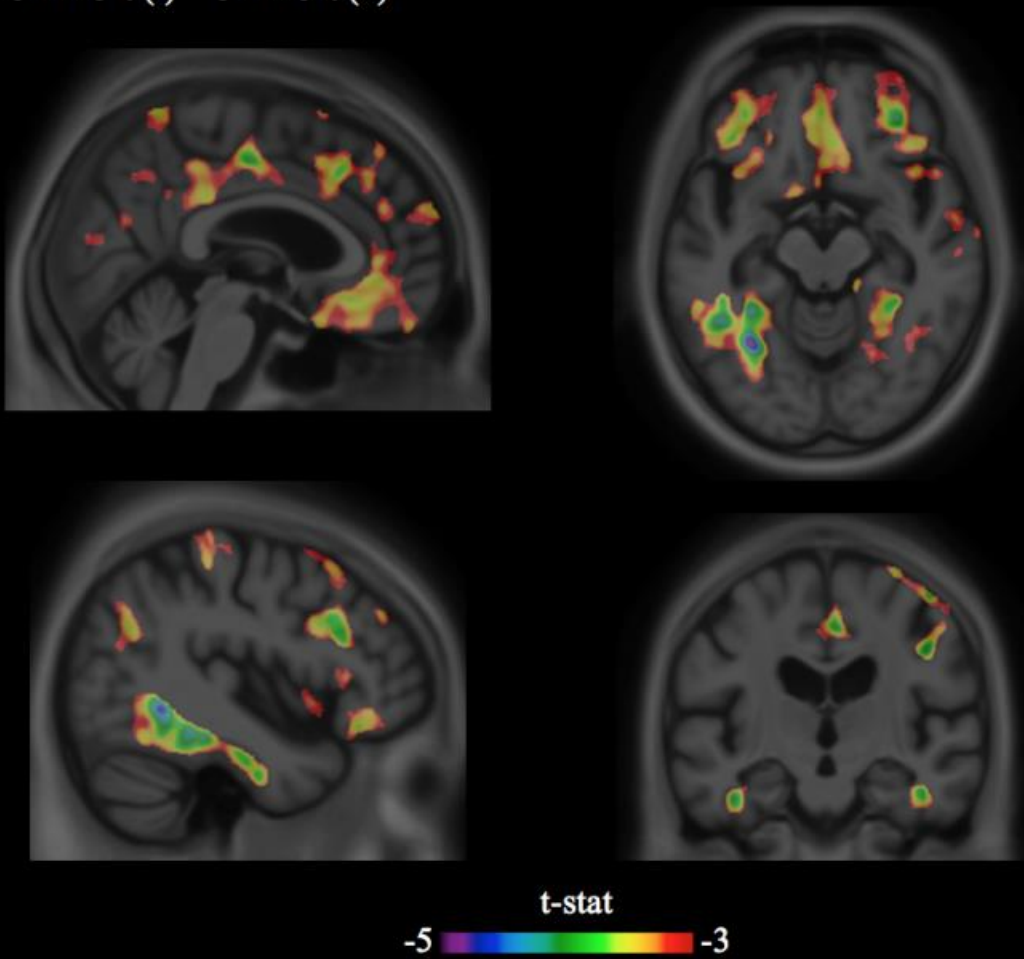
T-statistical parametric maps superimposed on an average structural MRI show brain regions with lower SUVR values in MA carriers (*CYP2C19* (+)) of the polymorphism in *CYP2C19*.
